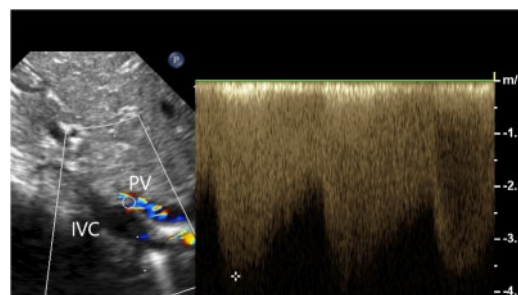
Echocardiogram, subcostal view: the aorto-collateral vessel was mistaken for an anomalous pulmonary vein draining to the inferior vena cava. IVC, inferior vena cava; PV, pulmonary vein.
